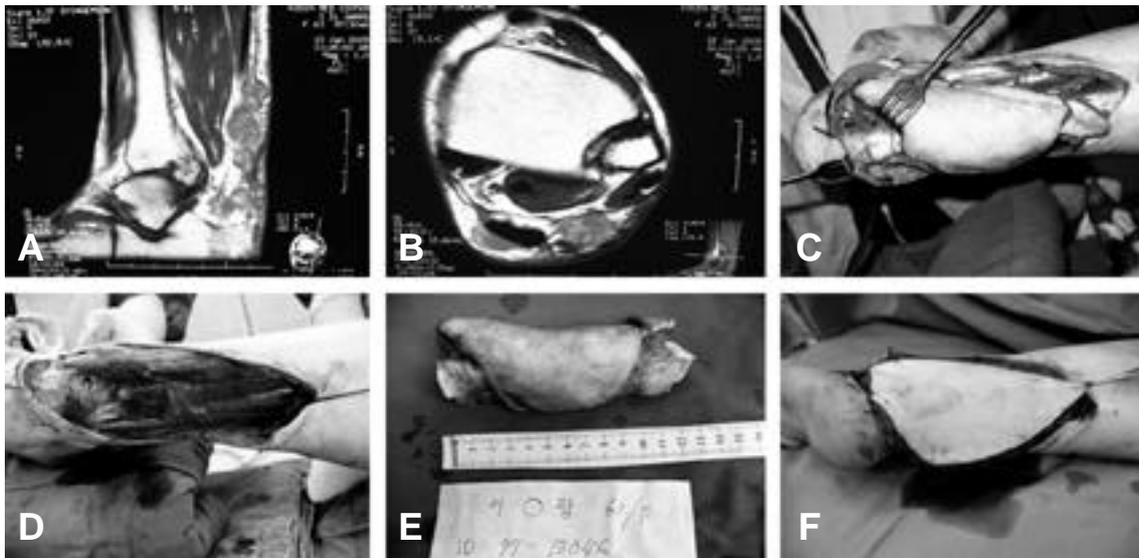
63 year-old female was surgical operated for malignant melanoma at ankle left and treated immunochemotherapy. After 2 years later, malignant melanoma was local recurred with tendocalcaneus. Reoperation was done by wide excision and recycled autogenous tendocalcaneus graft with extracorporeal irradiation and free flap. (A and B) are MR images after recurrence. (A) Axial T1 weighted MR image. (B) Coronal T1 weighted MR image. (C, D, E, F) are operation findings.
